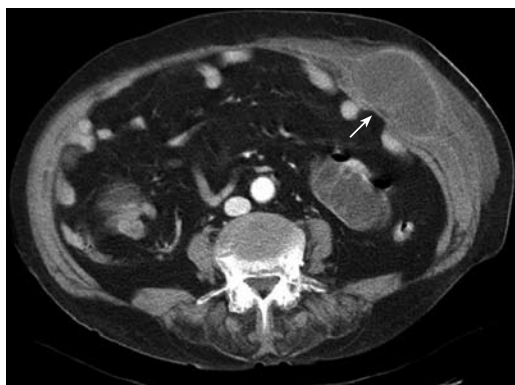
Port site hernia located at the left flank on computed tomography. Arrow indicates hernia.
